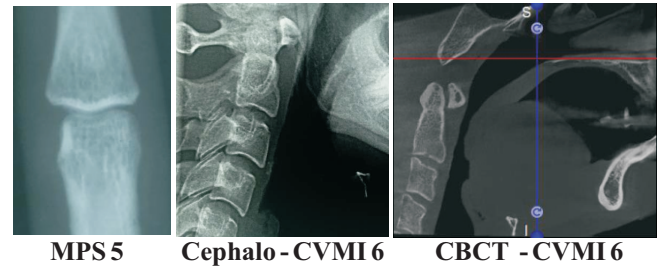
Sample case 1: Stages of skeletal maturity seen in sectional images of hand wrist radiograph (MPS), Lateral cephalogram (Cephalo-CVMI) and CBCT (CBCT - CVMI).
